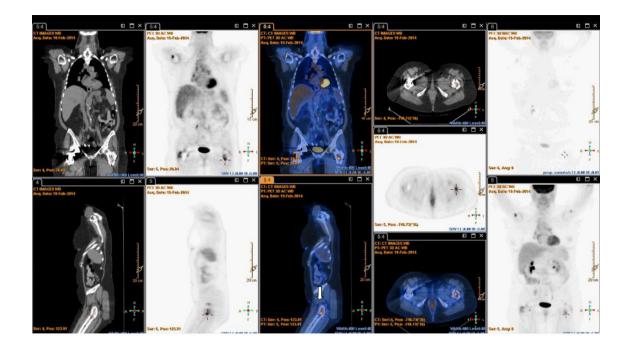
18FDG-PET/CT showed focus of FDG hypermetabolism at left proximal femur.
